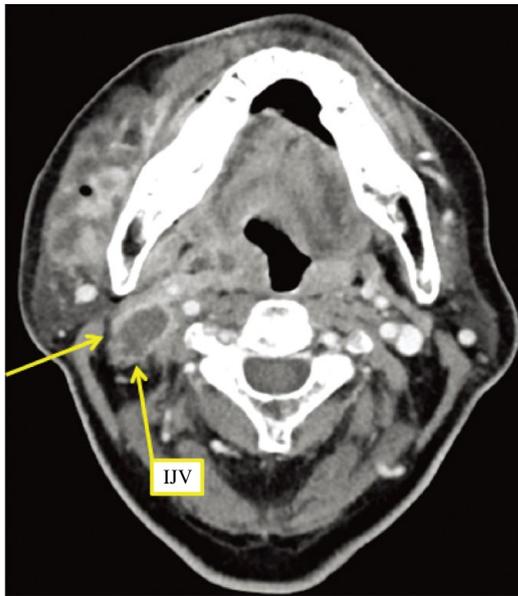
Contrast-enhanced CT scan shows thrombophlebitis of the right internal jugular vein with a thickened wall (Yellow arrow), and multiple abscess cavities are noted.
